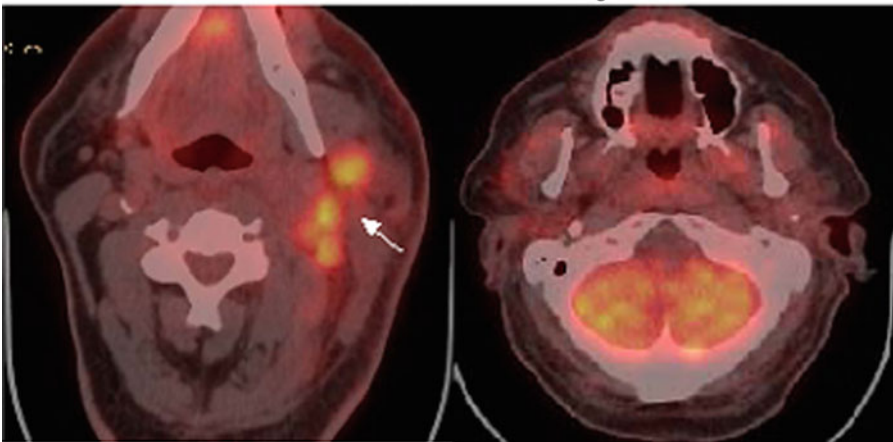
A 69-year-old male with carcinoma of the left parotid. Before chemotherapy, FDG-PET/CT images show extensive nodular hypermetabolism involving left head and neck, extending from left temporalis muscle region to left axillary nodes (*arrows*).
